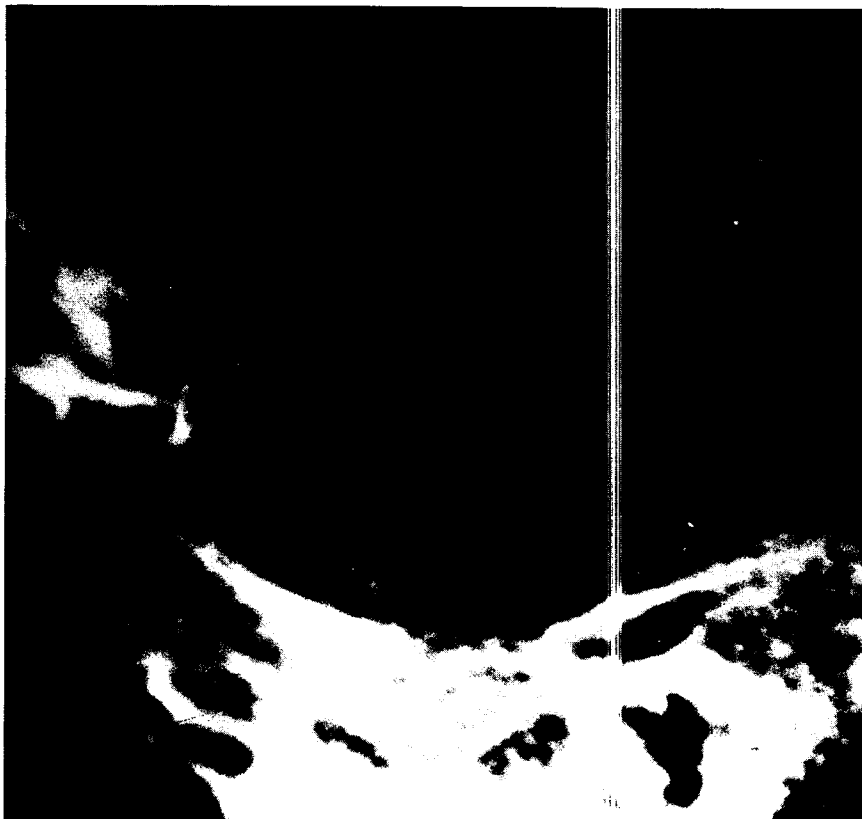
Lateral radiograph of pituitary fossa.
